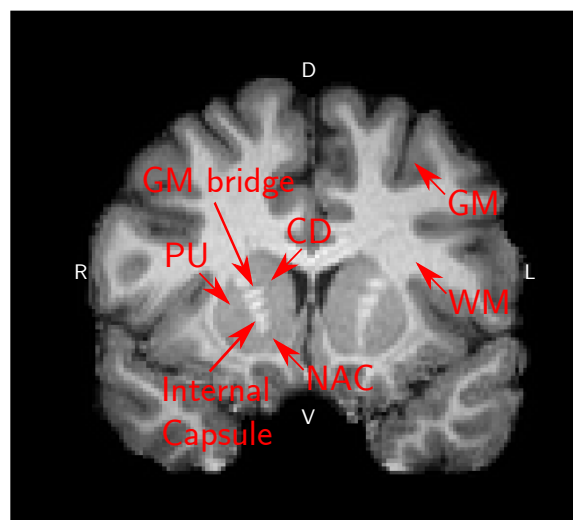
Anatomy of the striatum. A structural MRI image from a representative subject. CD: caudate; PU: putamen; NAC: nucleus accumbens; GM: grey matter; WM: white matter; R=right; L=left; D=dorsal; V=ventral.
